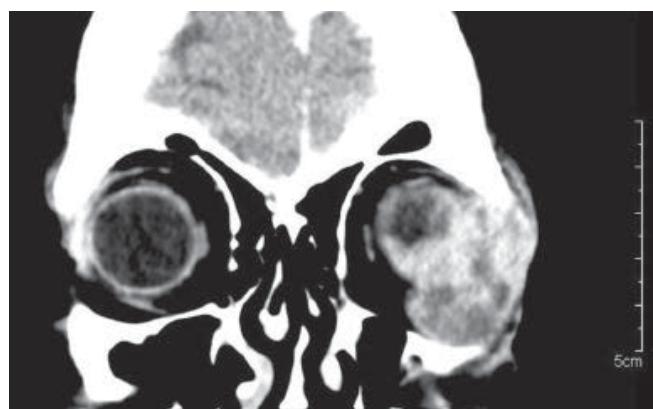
Massive infiltration of tissues of orbit on CT
